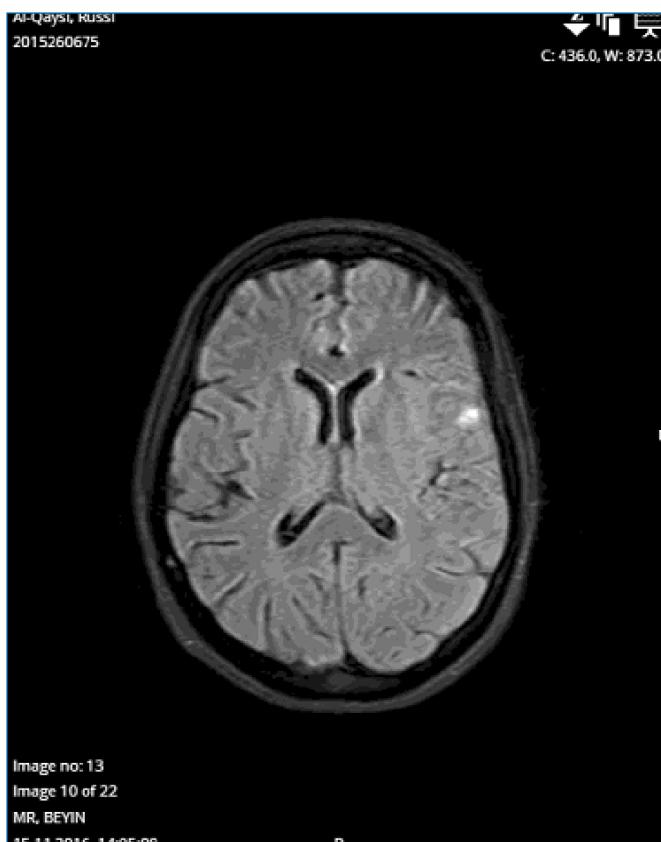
Cranial diffusion MRI: nodular hemorrhage area
